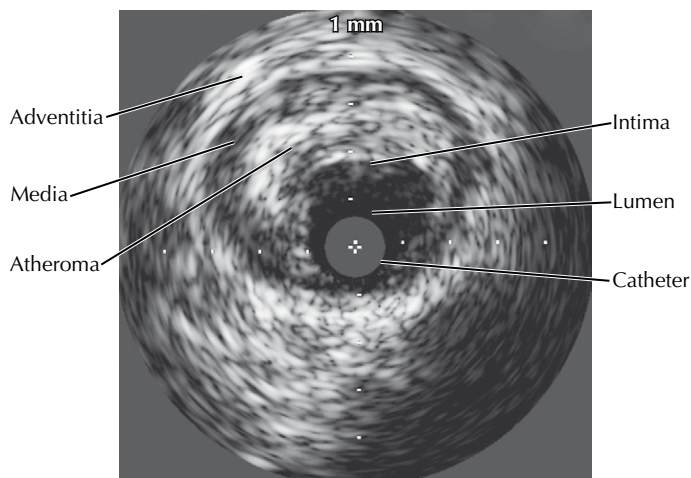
Intravascular ultrasonogram of coronary atherosclerosis.
